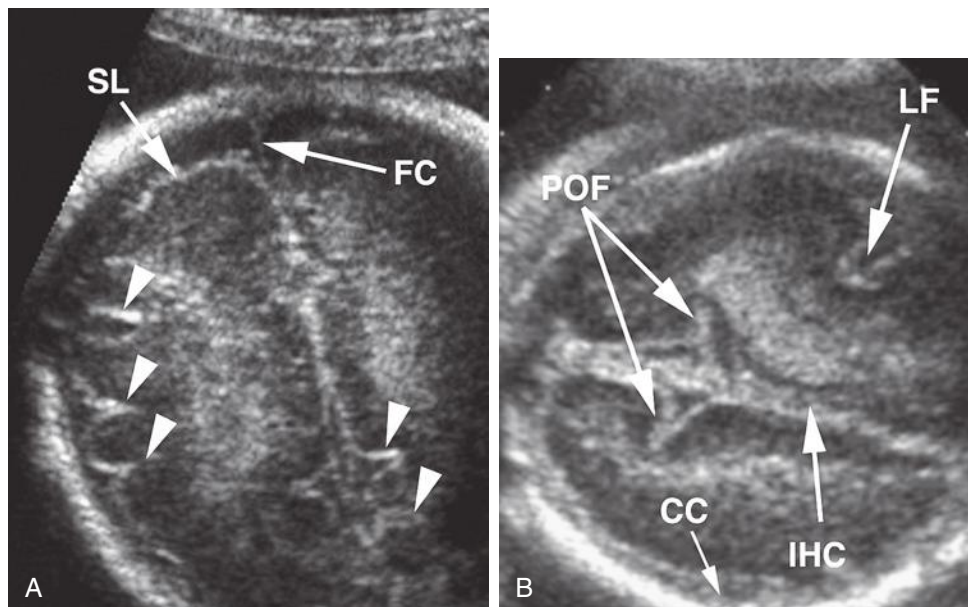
A, Older fetus. B, Younger fetus. Sonograms concentrating on the brain surface. In the younger fetus the brain surface is relatively smooth, although some of the major developing fissures are visible. In the older fetus, numerous sulci and gyri are visible (*arrowheads*). CC, convexity cistern; FC, falx cerebri; IHC, interhemispheric cistern; LF, lateral fissure; POF, parieto-occipital fissure; SL, surface leptomeninges.
